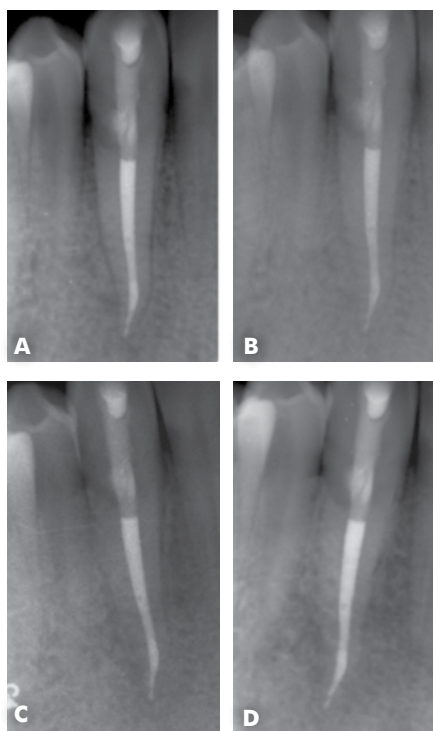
Review PA radiographs
